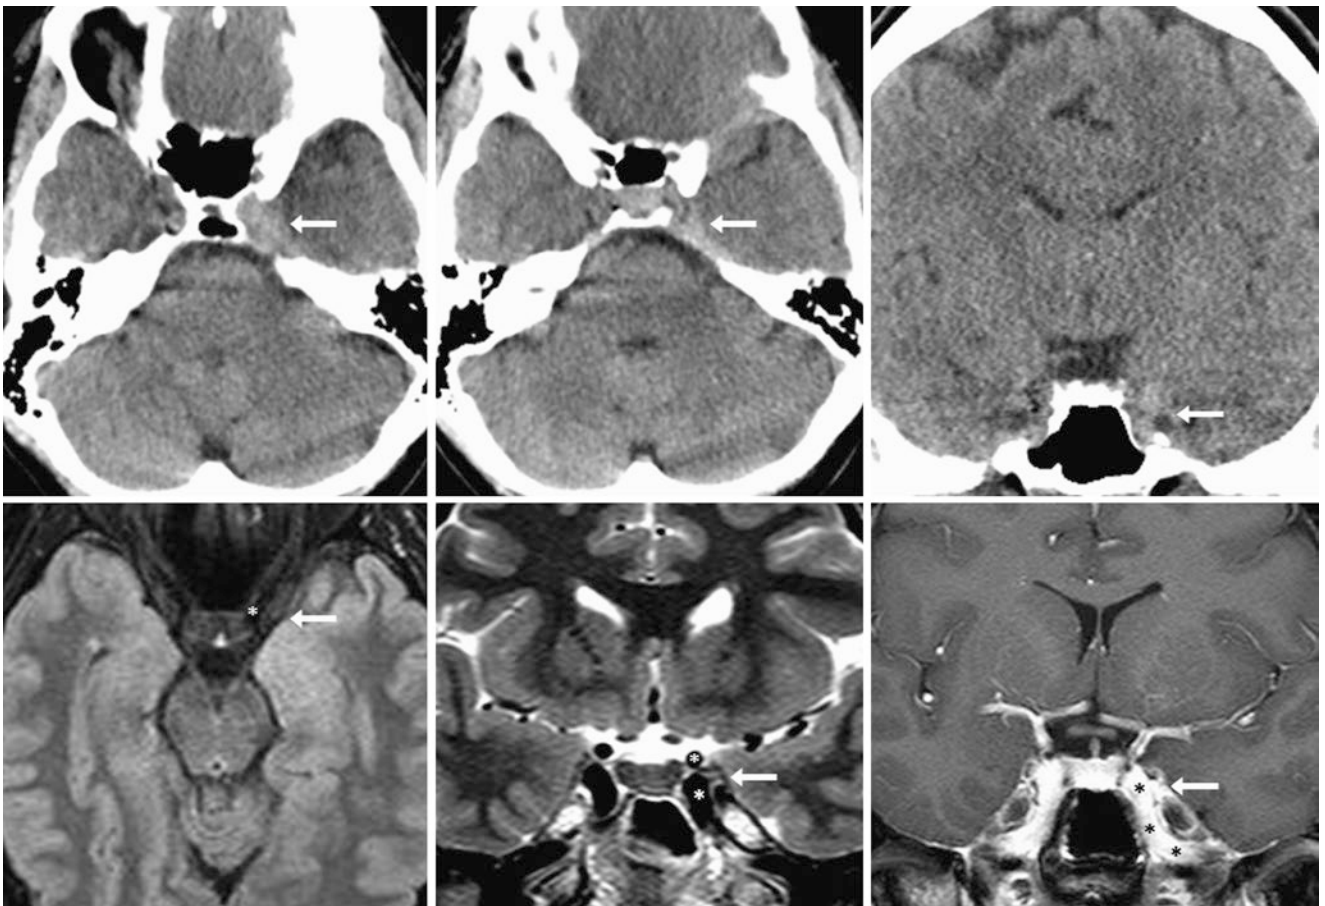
A 38 year old male with seizure, having prominence of the left cavernous sinus (arrow) on axial NECT (top left and top middle); coronal reformats (top right) were indeterminate. On 1.5 T MRI, axial
